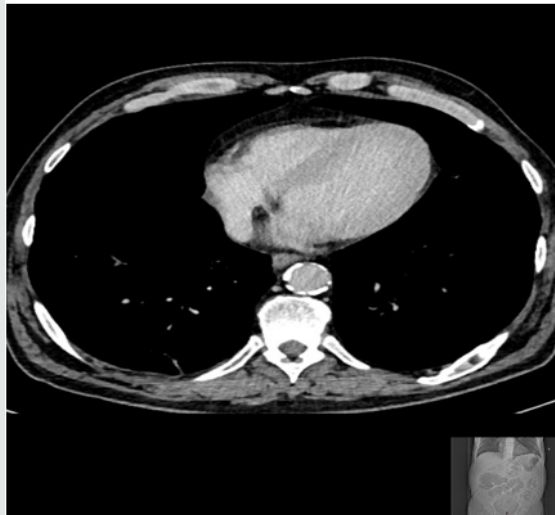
Chest-CT revealed no pleural effusion or mediastinal fluid collection.
